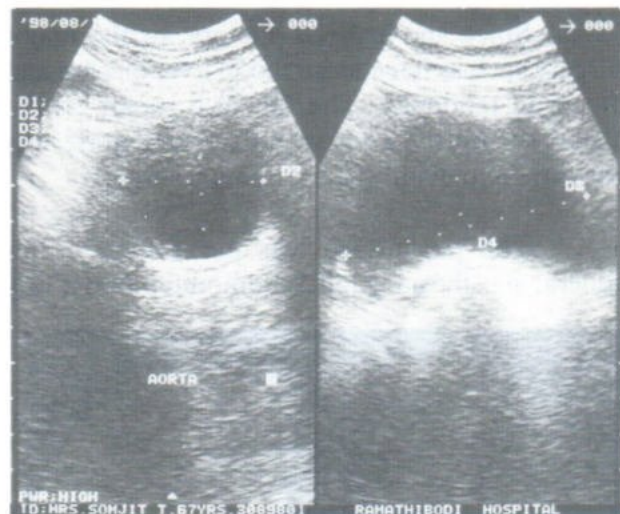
Ultrasound study showed a huge aortic aneurysm.
